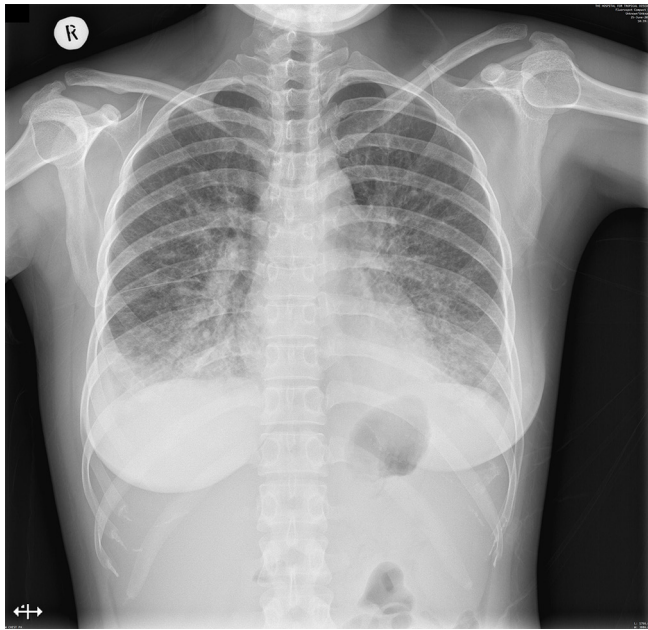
The chest radiograph showed bilateral interstitial infiltration, suggestive of bilateral pneumonitis.
